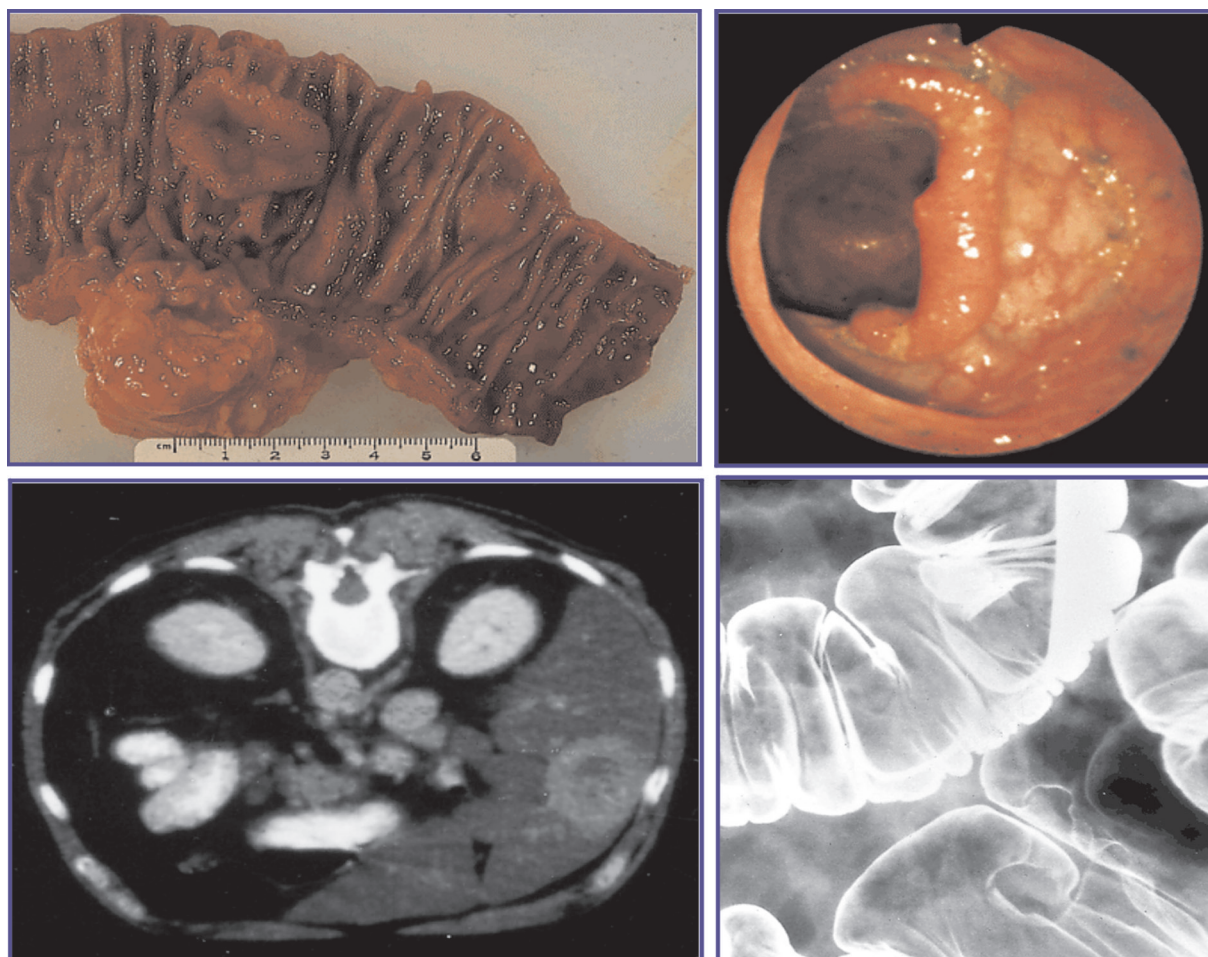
Examples of colorectal cancer of ascending sigmoid macroscopically and in CT (on left) and of caecum at endoscopy and radiology (on right)
